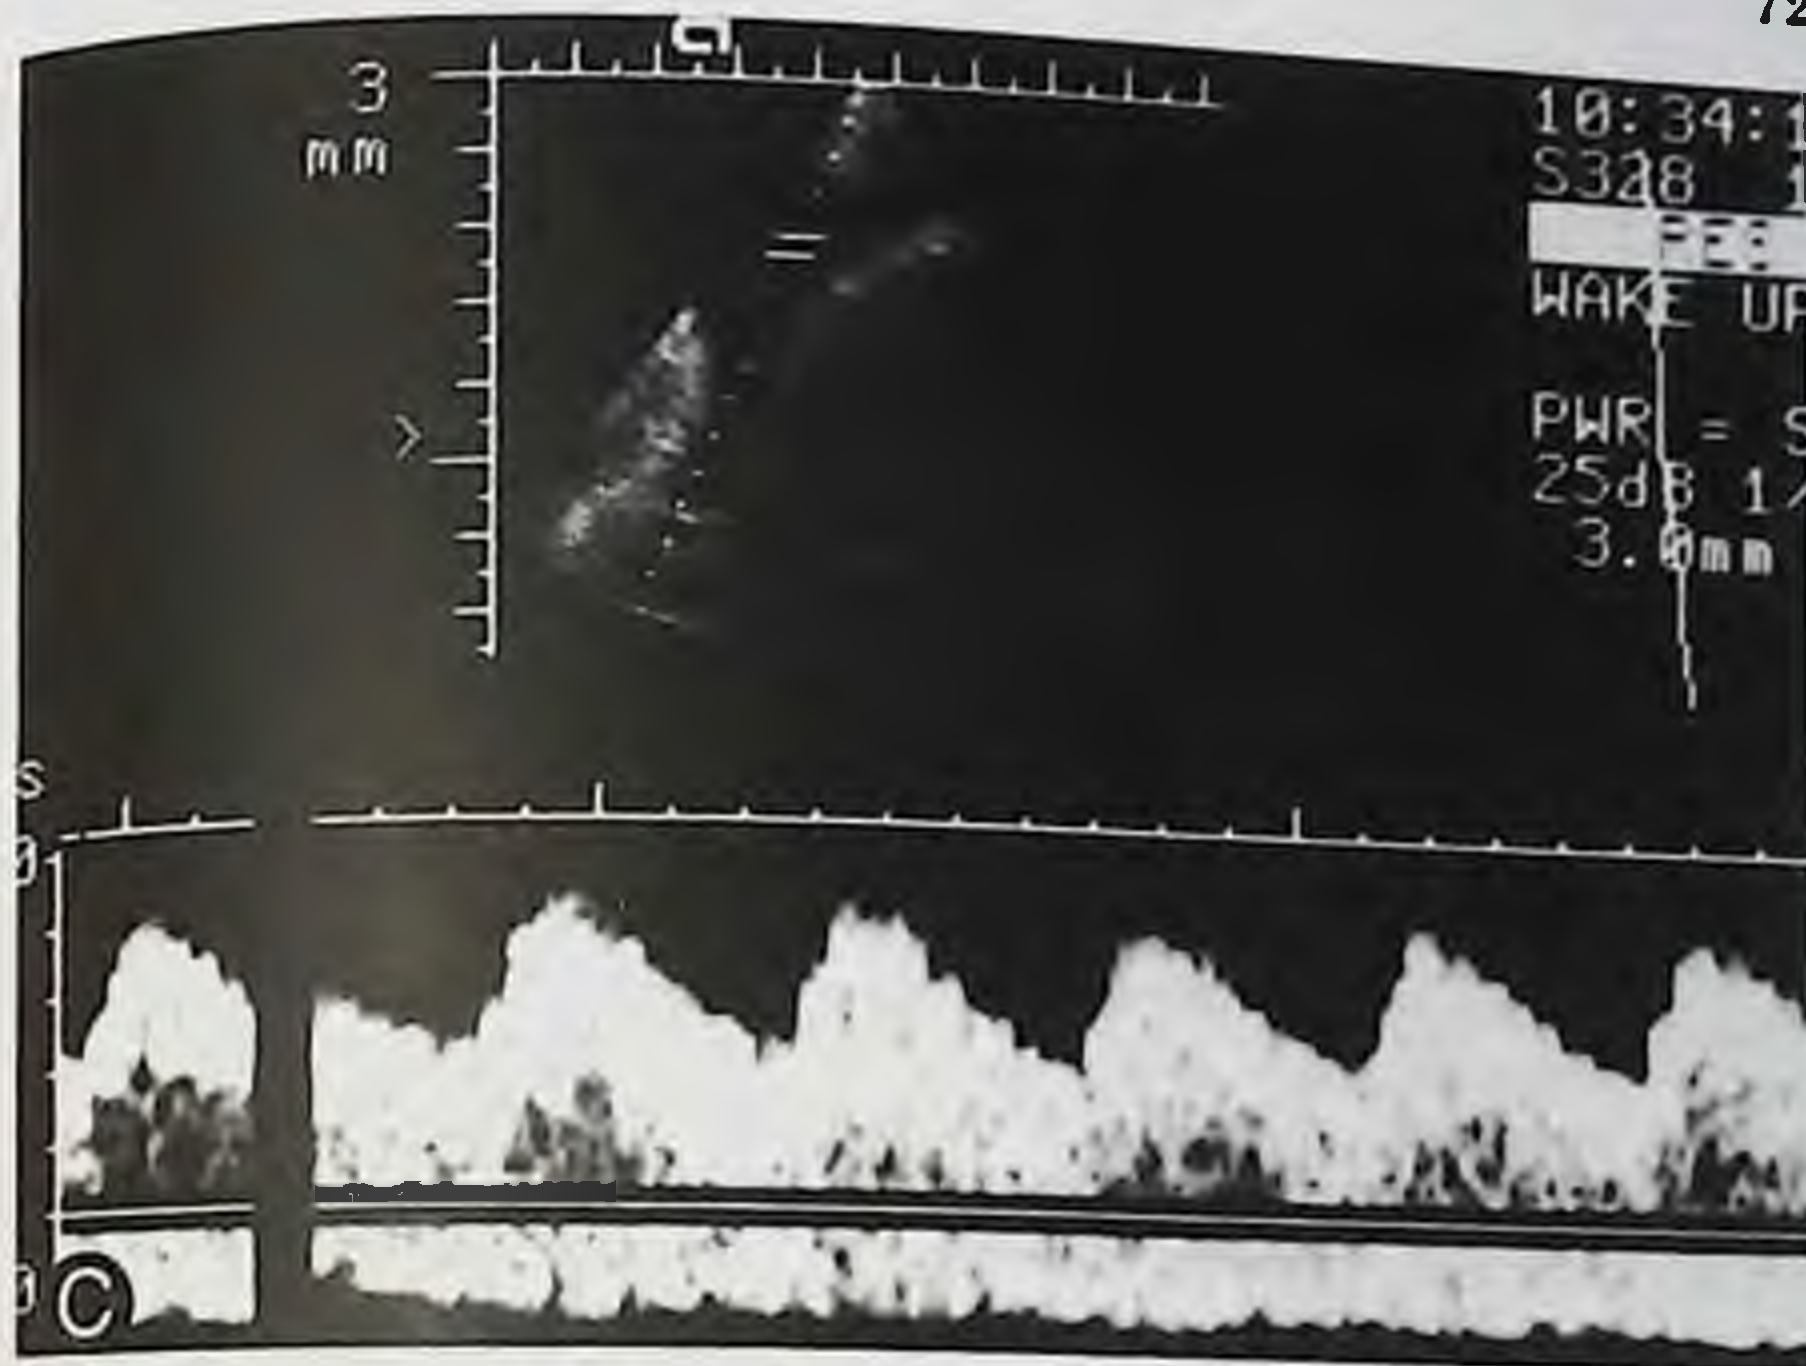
(Continued). C, Normal Doppler waveform analysis 24 hours later. This infant was delivered in good health at 38 weeks' gestation.
